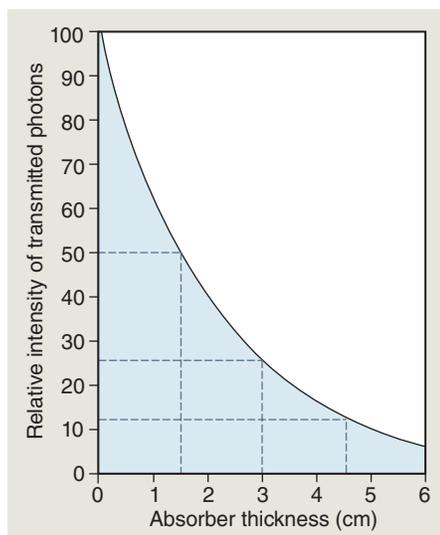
Intensity of an energetically homogeneous x-ray beam declines exponentially as it travels through an absorber. In this instance, the half-value layer of the beam is 1.5 cm of absorber (i.e., every 1.5 cm of the absorber reduces the intensity of the beam by half). The curve for a heterogeneous x-ray beam (e.g., a dental x-ray beam) does not drop quite as precipitously because of the preferential removal of low-energy photons by the absorber and the increased mean energy of the resulting beam.
